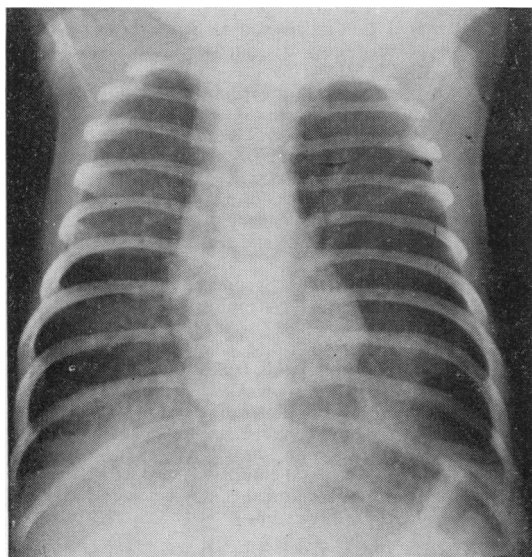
Chest roentgenogram showing pronounced hyperinflation and diffuse increase in the interstitial markings of both lungs.
